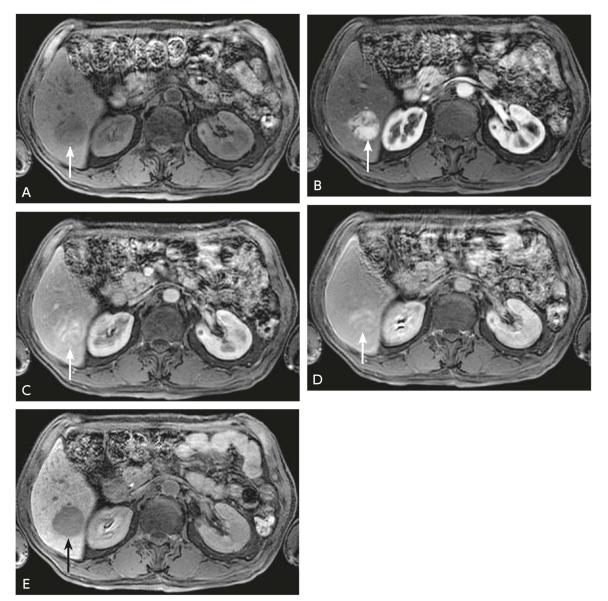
EOB-MRI (moderately differentiated hepatocellular carcinoma)
